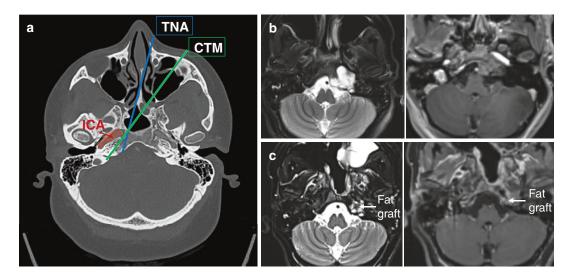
(a) Computed tomography angiography (CTA) demonstrating the improvement in the angle of approach to the petrous apex relative to the horizontal petrous internal carotid artery (ICA) with the contralateral transmaxillary approach (CTM) compared to traditional transmasal approach (TNA). (b) Magnetic resonance imaging (MRI)
